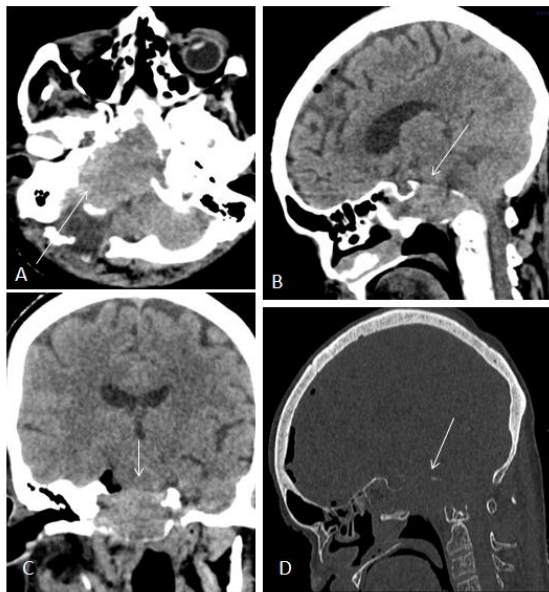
(A, B, C) Representative CT sections in brain window in axial, sagittal and coronal cuts showing a large irregular expansile lytic lesion with soft tissue component epicentred within the clivus (white arrows). (D) Sagittal section in bone window showing expansile lytic lesion showing cortical destruction of the entire clival bone (white arrow). HPE: Chordoma.
